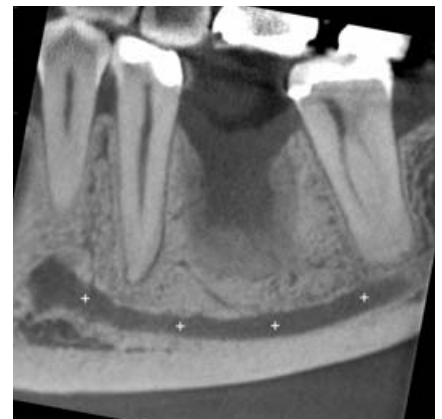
Sagittal CBCT image
